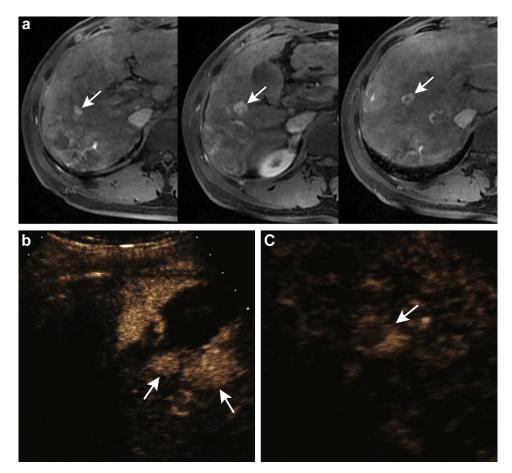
Multifocal hepatocellular carcinoma (HCC) lesions in a 52-y-old man. (a) Contrast-enhanced MRI performed during the arterial phase shows multifocal viable tumor lesions (arrows) among many large regenerative nodules in advanced cirrhotic liver. (b, c) Before the RF ablation, contrast-enhanced ultrasound (CEUS) images obtained during the arterial phase identify the true HCC nodules (arrows).
